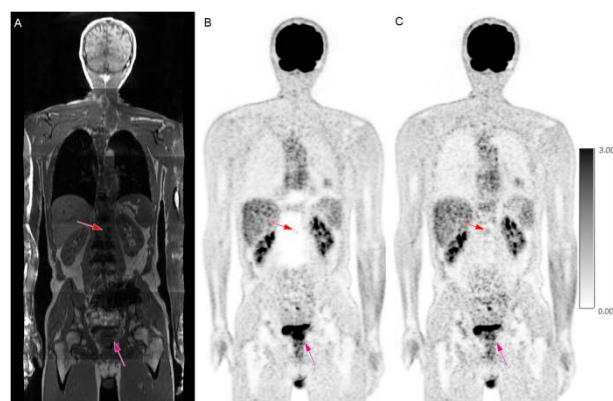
A patient with thoracolumbar spinal fusion: A) T1 weighted MRI, B) non-TOF PET, C) TOF PET. In the non-TOF PET image a spinal bone metastases is obscured (red arrow) due to the metal artifacts also shown in the MRI. (PET range 0-3 g/ml)
